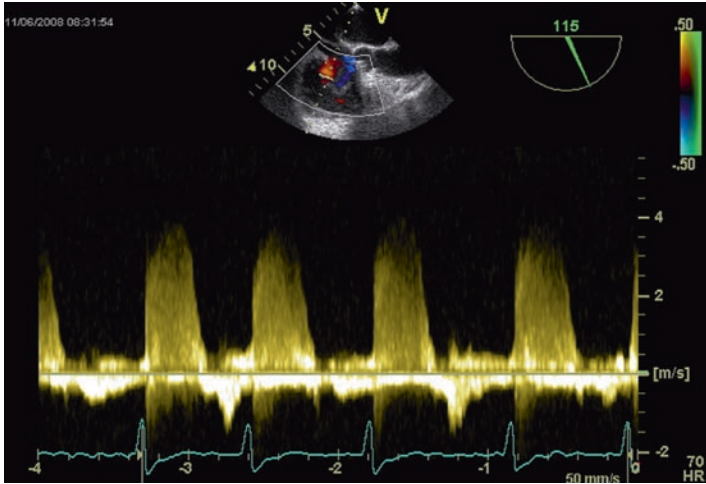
Continuous wave Doppler recording of a tricuspid regurgitant jet that could be used to estimate the right atrial to right ventricle pressure difference.
